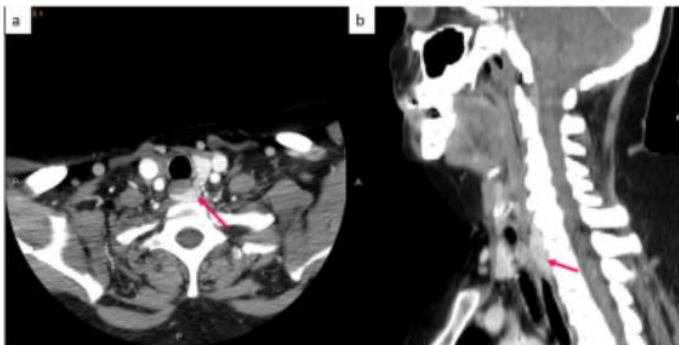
CONTRAST-ENHANCED CT OBTAINED 35 S AFTER CONTRAST ADMINISTRATION. ADAPTED FROM (9).
